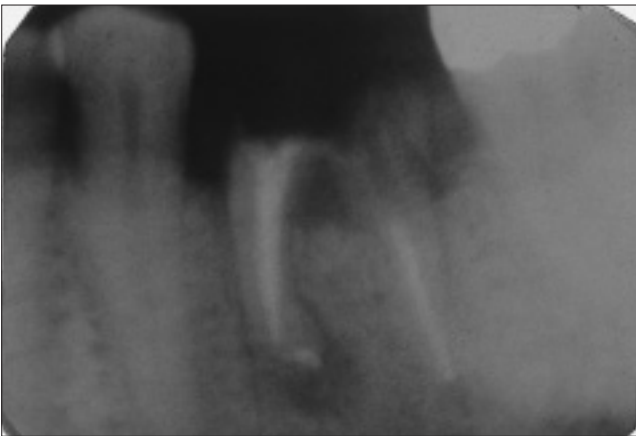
Preoperative periapical radiograph of tooth 36.
